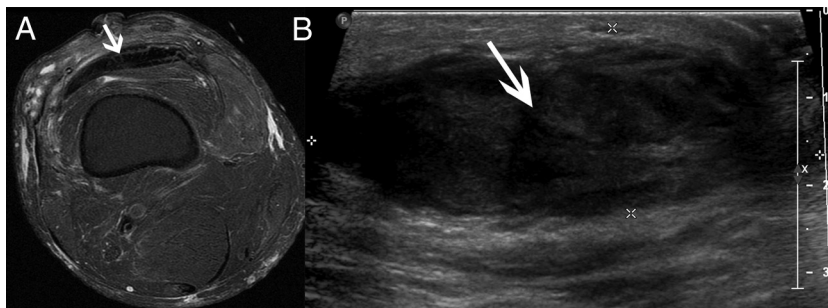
(A) Magnetic resonance imaging (axial view): 5.6-by-4.2-by-1.3-cm anterior loculated fluid collection and diffuse edema. (B) Ultrasonography: 5.8-by-2.1-cm heterogeneous collection in prepatellar area.
